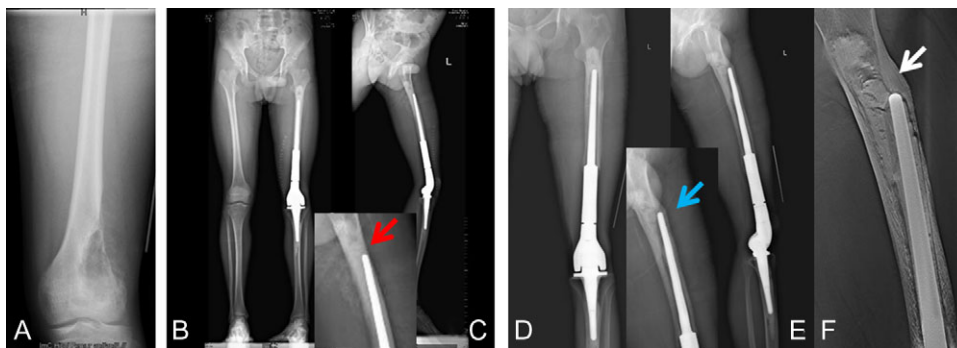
The preoperative, postoperative and 3 years follow-up radiographs of Patient 1 during the previous surgery. (A) the anteroposterior preoperative radiograph; (B, C) the immediate postoperative anteroposterior and lateral radiographs, the red arrow shows the tip of the stem had to deviate to the anterior part of femur; (D,E) the anteroposterior and lateral radiographs at 3 years follow-up, the blue arrow shows the aseptic loosening of stem and the bone hyperplasia; (F) the T-SMART image at 3 years follow-up, the white arrow shows that the breakage of cement and the aseptic loosening of the stem.
